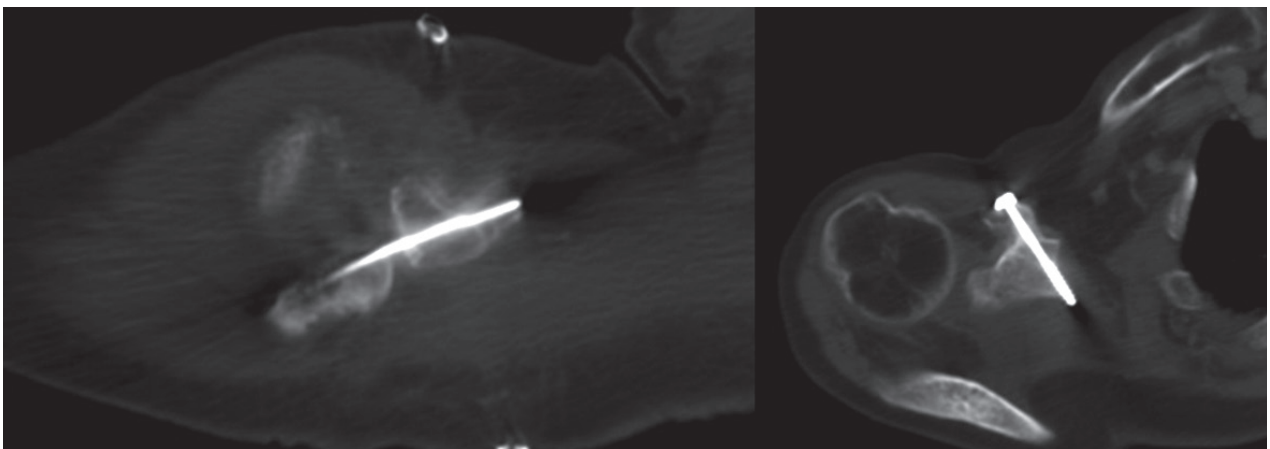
a-b. Postoperative CT-scan shows the internal fixation of the graft to the host bone
